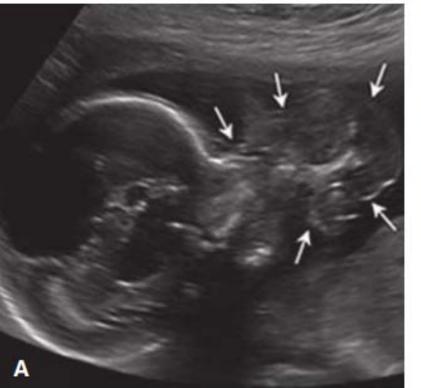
Epignathus, ultrasound (A) and postdelivery (B) from the oral cavity or pharynx and may grow outward from the and into the brain, as in this fetus (*arrowhead*). Arrows depict the (Reproduced with permission from Halima Abdirahman, RDMS.)
